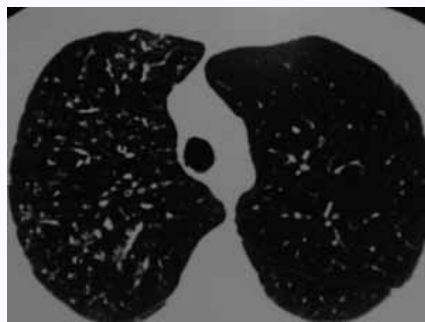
HRCT showing centrilobular nodular process with 'tree in bud' appearance more marked on the right.
